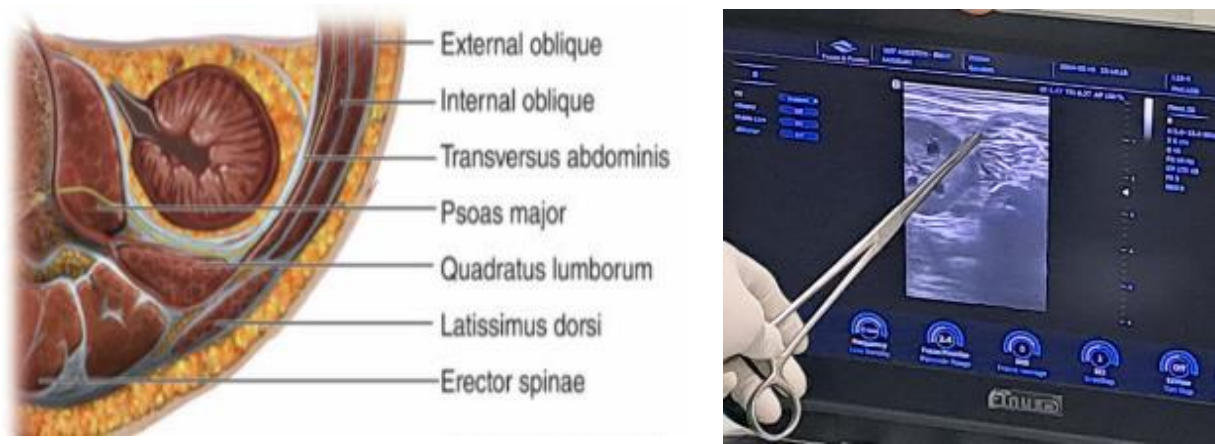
Position of Quadratus Lumborum on ultrasound
